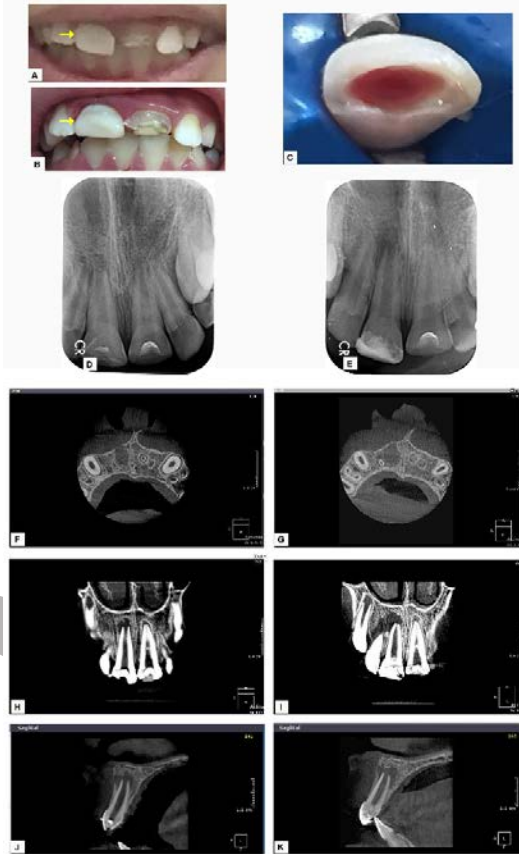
Case #2 tooth #8. A: Preoperative photograph showing an acrylic crown, B: Postoperative photograph, C: Intraoperative photograph showing induction of bleeding, D: Preoperative periapical radiograph, E: After twelve months follow up periapical radiograph showing an increase in the size of the lesion, F,H,J: Preoperative CBCT showing the lesion in axial, coronal and sagittal planes respectively, G,I,K: After twelve months follow up CBCT in axial, coronal and sagittal planes showing an increase in the size of the lesion, I: Coronal plane showing narrowing of the apical diameter.
